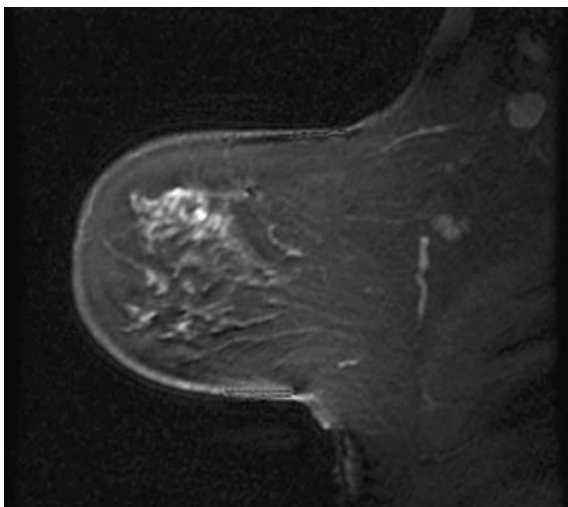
This is a recurrence anterior to the lumpectomy site in the left breast of a 49-year-old female; her mammogram was normal and this was detected on a screening MRI. The MRI showed regional ductal enhancement in the upper outer quadrant of the left breast
